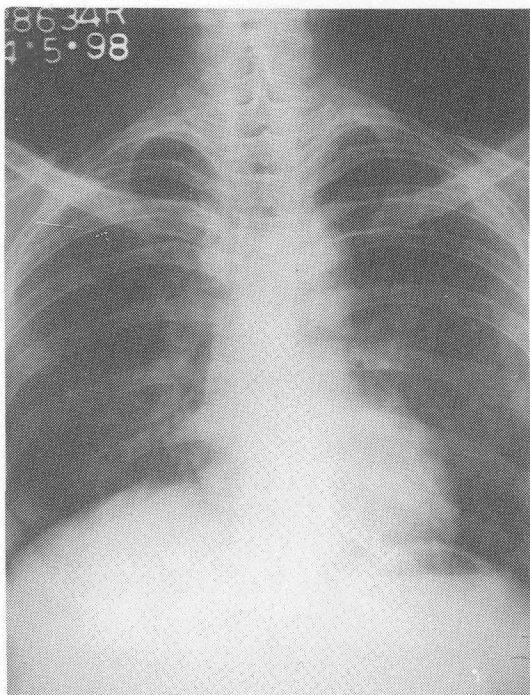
Chest radiograph reveals reticular pattern in the mid and lower zones.
